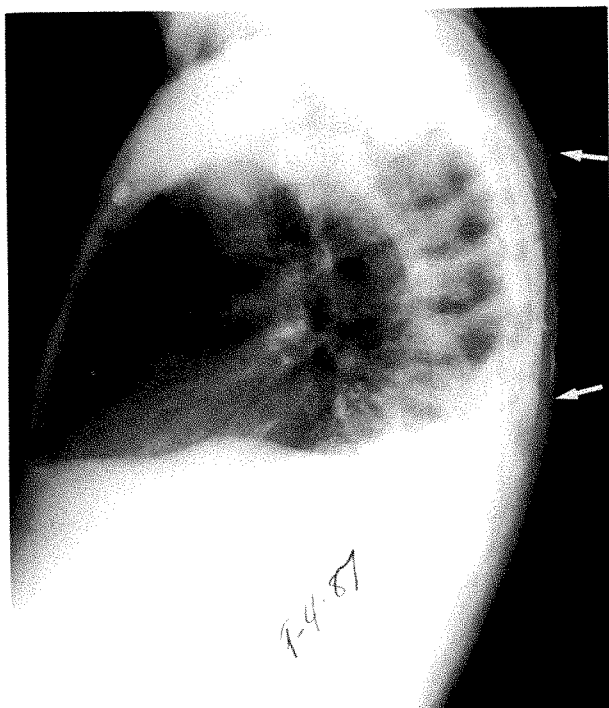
Chest x-ray (lateral view) with arrows showing margins of spread of contrast following injection of contrast medium through the catheter. Counter-clockwise rotation of the patient (i.e., note sternum) makes contrast appear more posterior anatomically. Subpleural location is indicated as spread of contrast appears to be posterior to vertebral body chain.
